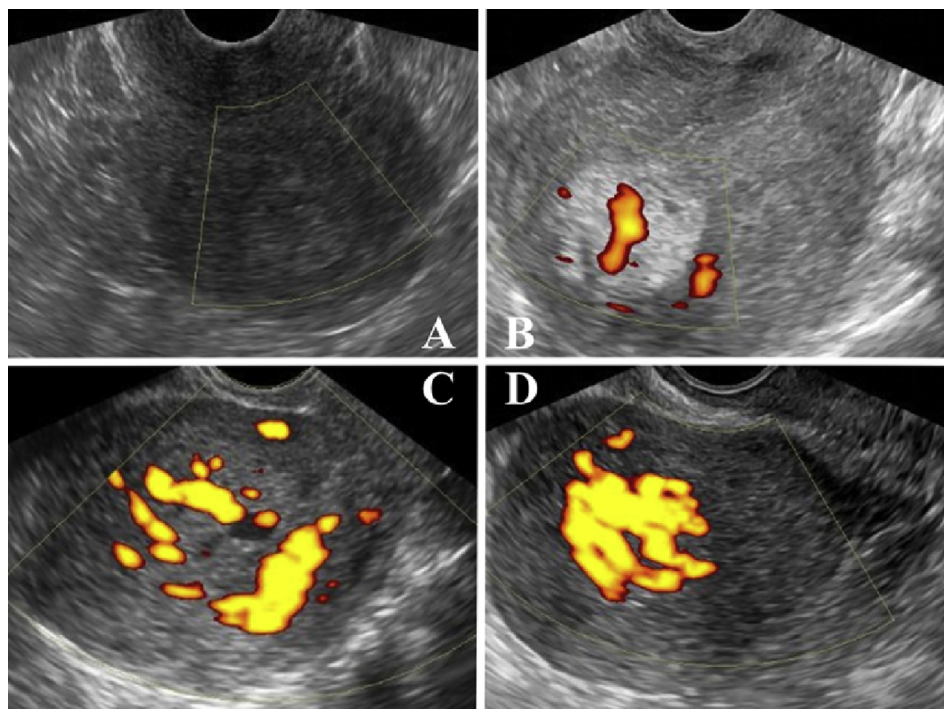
Power Doppler color score (PDCS) as the vascularity parameter of placental polyps. (A) PDCS 1 (no detectable blood flow), (B) PDCS 2 (minimal flow), (C) PDCS 3 (moderate flow), and (D) PDCS 4 (highly vascular).
